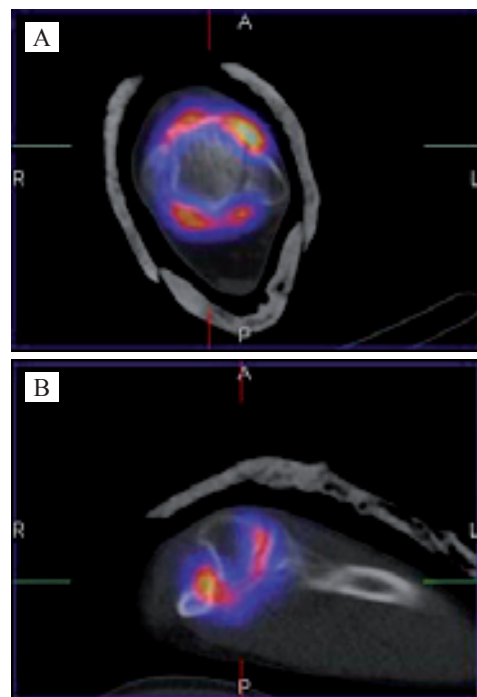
Fusion images (SPET/low dose CT), transverse view of left ankle (A) and right elbow (B). Homogeneous distribution of ¹⁸⁶Re-S is seen intra-articularly.
